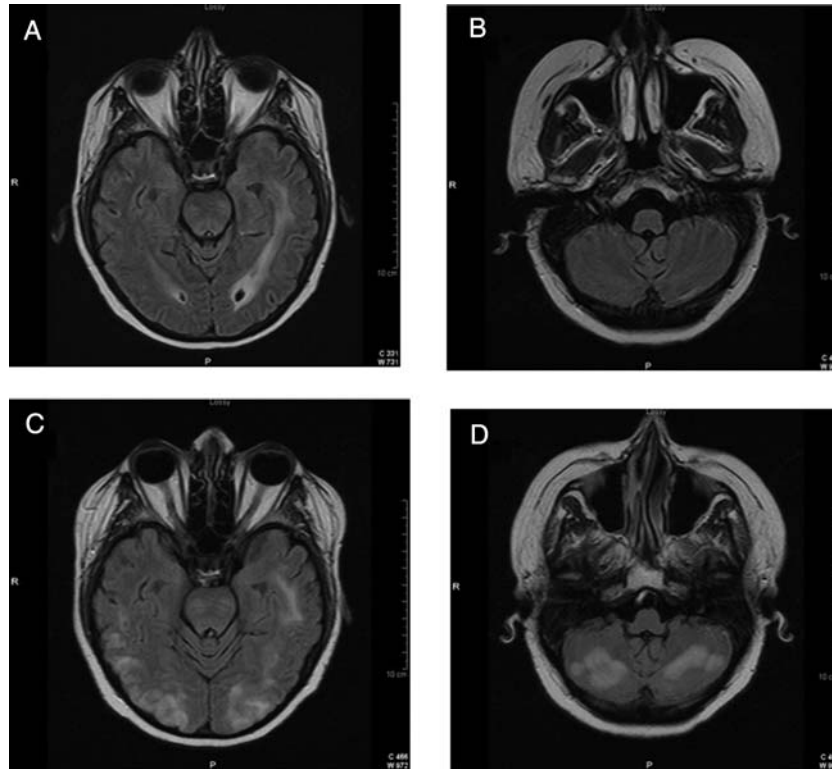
Reversible posterior leukoencephalopathy syndrome (RPLS): This 47-year-old woman had an 18-month history of a corpus callosum glioblastoma that progressed despite radiation with temozolomide, temsirolimus with sorafenib, and then BCNU (Carmustine). She presented 3 weeks after starting bevacizumab with headache, seizures, unresponsiveness, and blood pressure of 160/100 mm Hg. FLAIR-weighted MRI sequences 2 weeks before (A and B) and 3 weeks after her first dose of bevacizumab (C and D).
